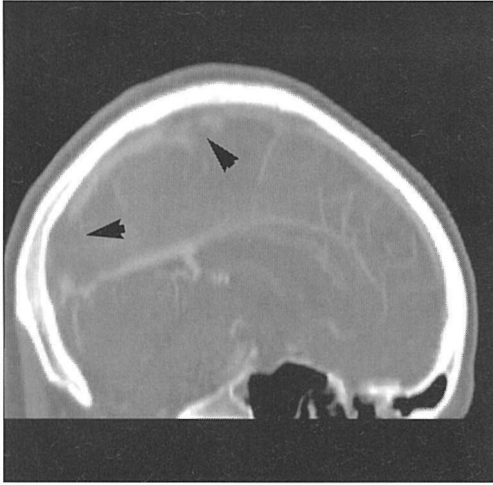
CT angiogram, multiplanar reconstruction, sagittal reconstruction, shows absence of opacification in posterior and middle portion of superior sagittal sinus because of thrombosis (arrows).
